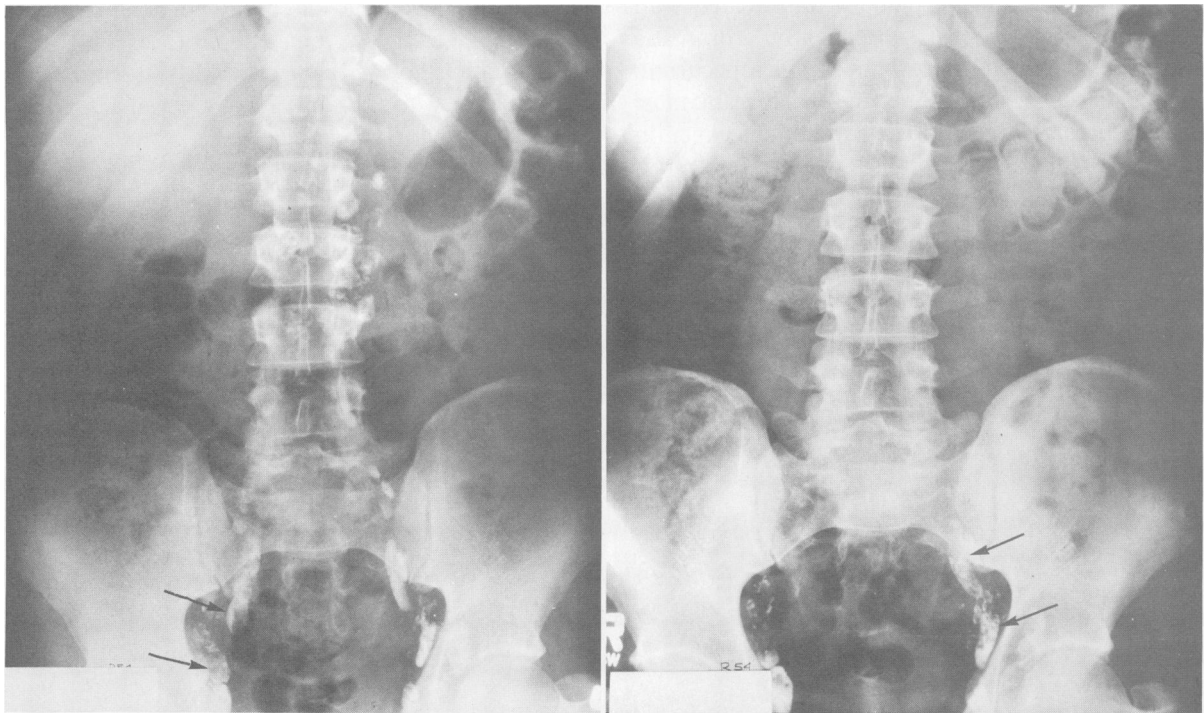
Left, initial lymphangiogram demonstrated radiographically positive right iliac nodes (arrows). All of the lymph node areas below the diaphragm were irradiated (inverted "Y"). Right, two years later, a repeat study was performed because of symptoms suggesting recurrent disease. Radiographically involved left iliac nodes were now shown and confirmed by biopsy.
